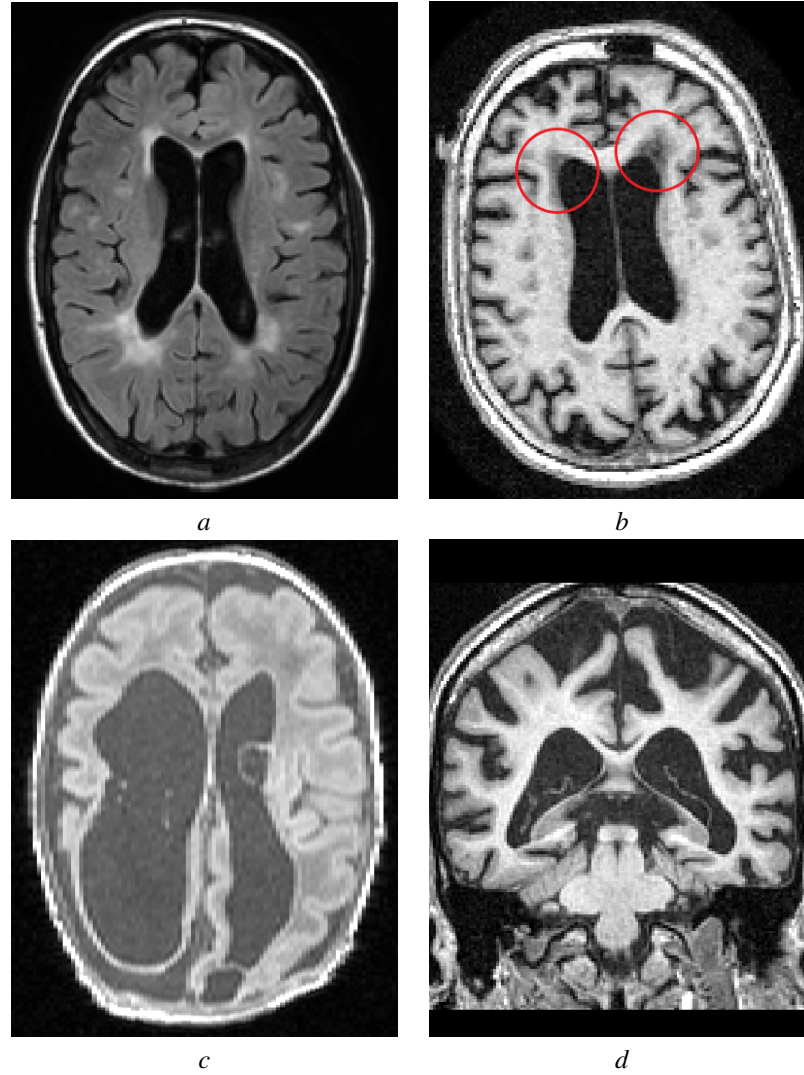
Four examples of challenging brains to segment: (a) FLAIR MRI of a multiple sclerosis patient with WM hiperintensities; (b) T1-weighted MRI image a dementia patient with periventricular WM damage; (c) T1-weighted MRI image of a neonatal brain with ventriculomegaly, resulting in a collapsed cerebrum; (d) T1-weighted MRI image of an highly atrophied brain of a patient with Alzheimer's disease.
